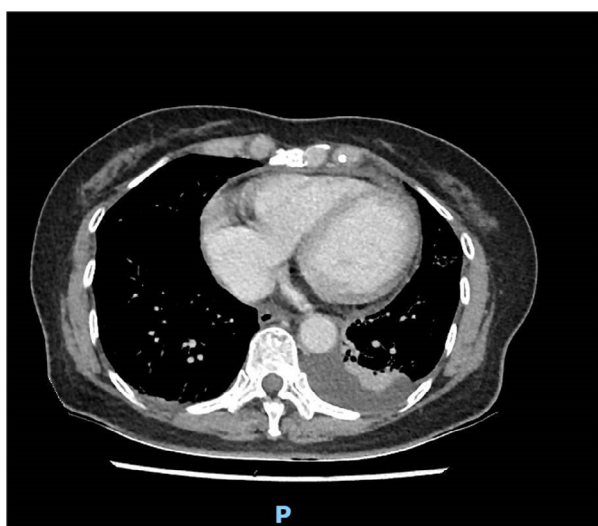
Computed tomography of the chest on admission
